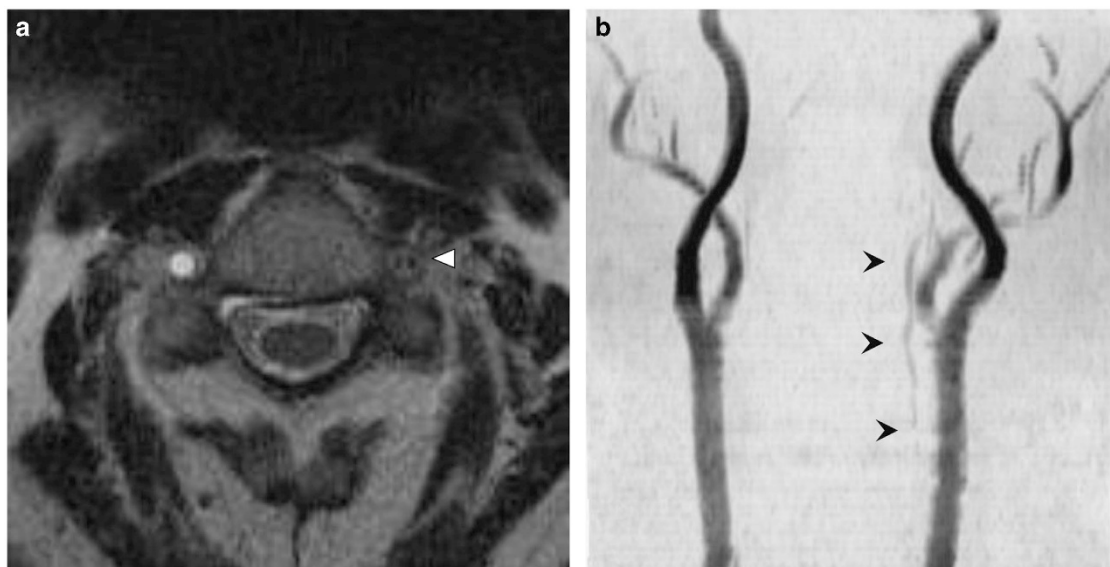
MR image of the cervical spine (a) and MR angiography of the neck (b) performed at the 3-month follow-up. Blood flow of the left side vertebral artery was slightly restored.
